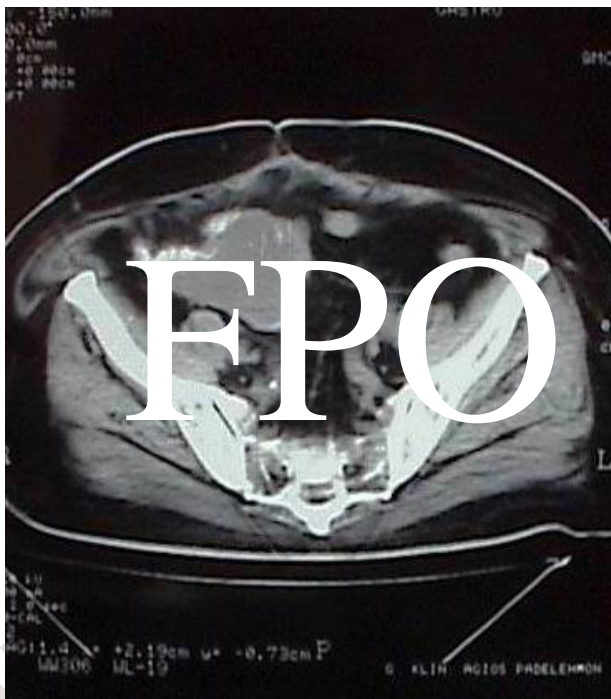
Computed tomography scans demonstrate a 5 \times 7 cm cystic collection at the area of the primary appendiceal tumor following an anastomotic leak.
